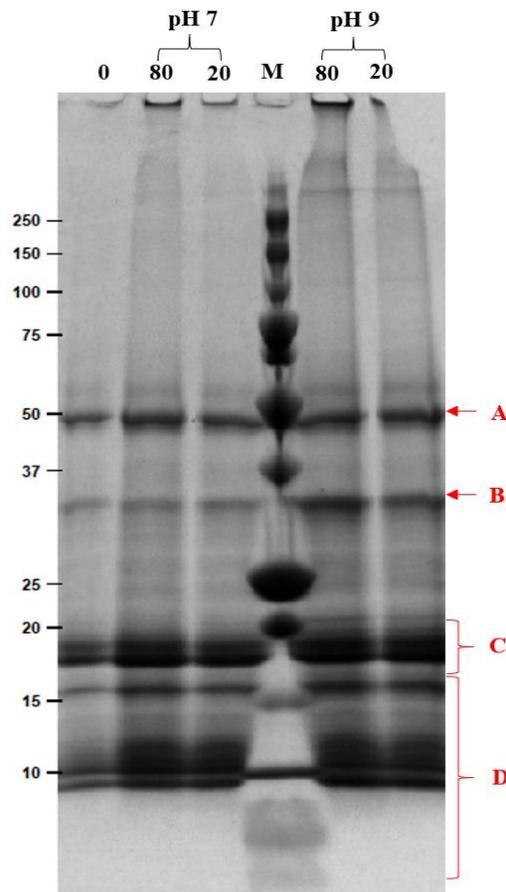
SDS-PAGE comparison of hemp proteins extracted by ultrasound at different amplitude (20% and 80%) at different pH (pH 7 and pH 9) at 65 °C. Numbers above the lands indicate the used amplitude in percentage; 0, sample without ultrasound. M, molecular mass weight marker in kDa; Bands A-D most likely indicate globulin and albumin fractions of hemp proteins, see text for more details. The protein concentration for all samples in the SDS-PAGE loading buffer was adjusted to 1 mg/mL before loading.
